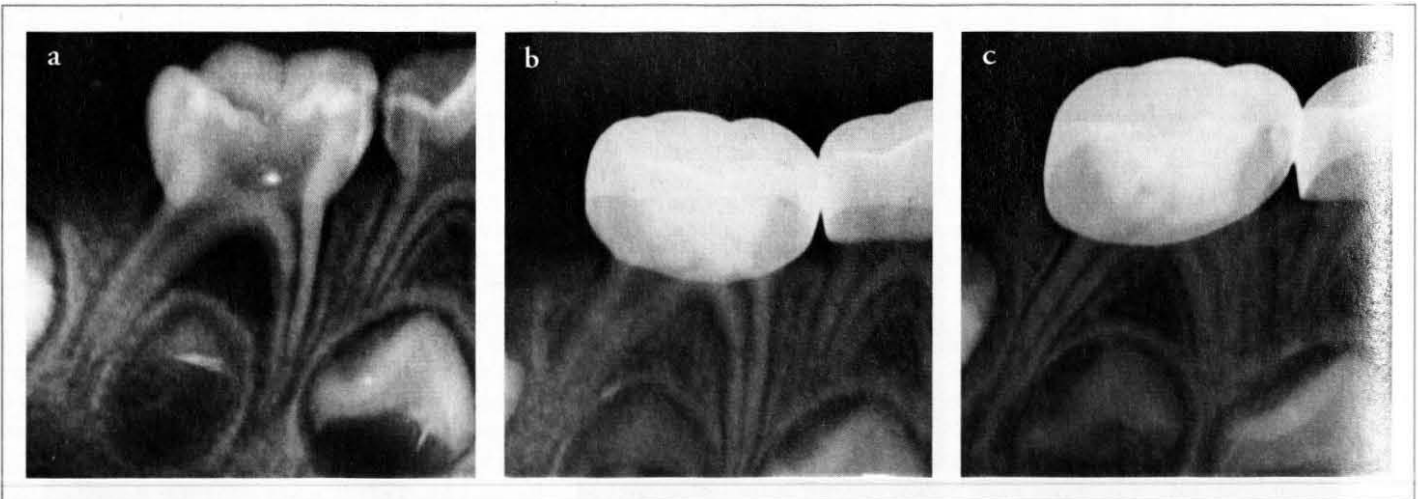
(a) Initial periapical radiograph showing occlusal caries extending into the pulp chamber with a furcation radiolucency overlying the permanent tooth bud. (b) Four months post-op, the periapical radiograph demonstrated increased trabeculation in the furcation area. Slight internal resorption noted in the distal canal. (c) Ten months post-op, radiographic findings demonstrated stability of the inter-radicular and periapical structures and a normal periodontal ligament space. Internal resorption in the distal canal has resolved.
